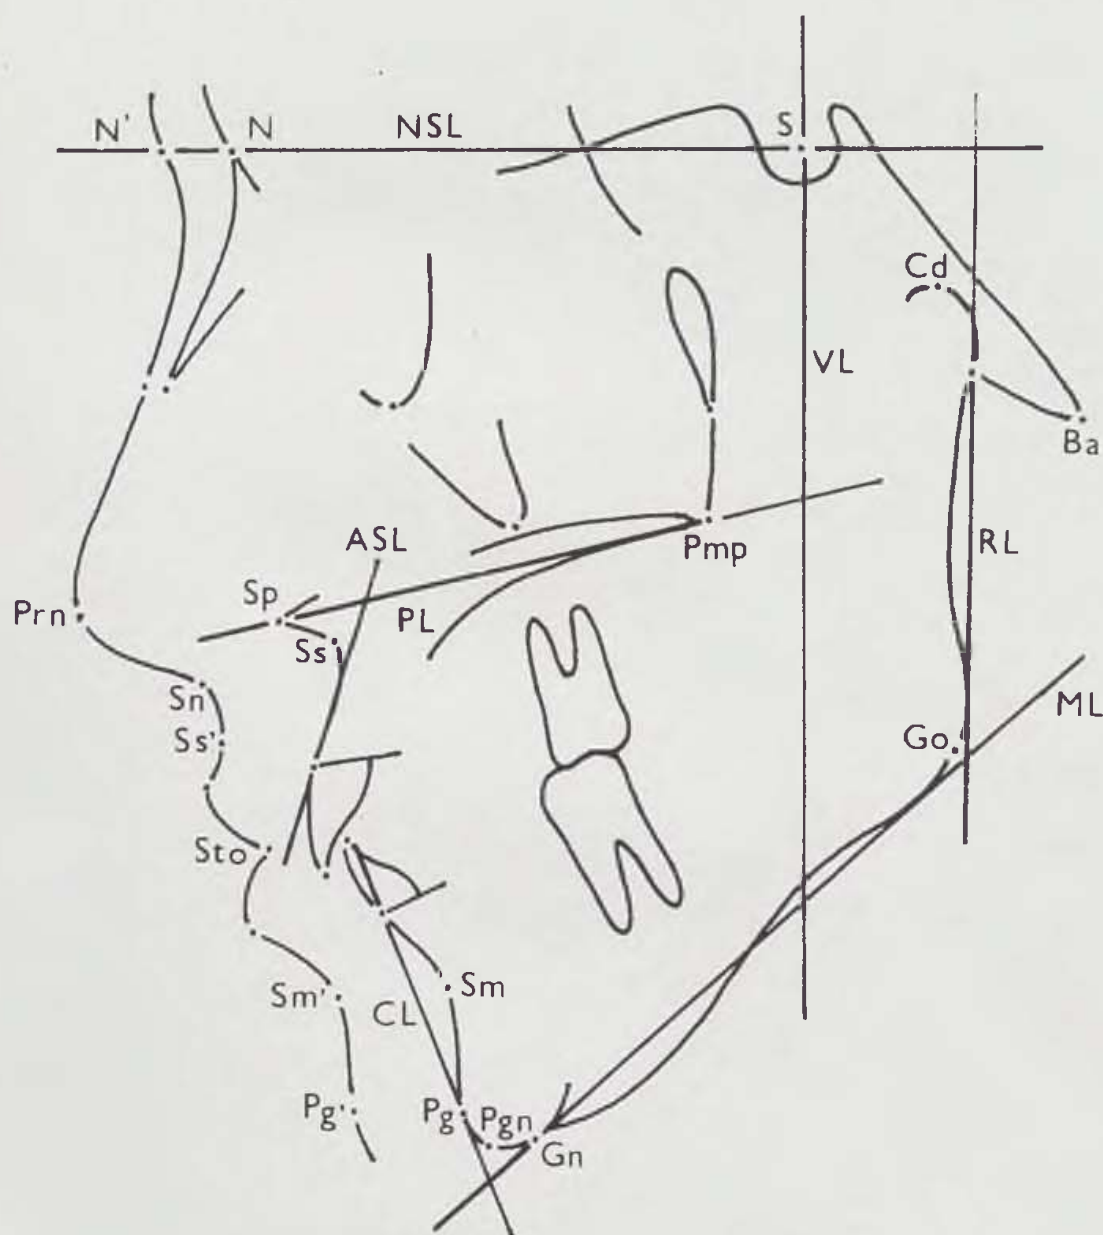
Cephalometric points and reference lines used for the assessment of lateral X-ray films.
